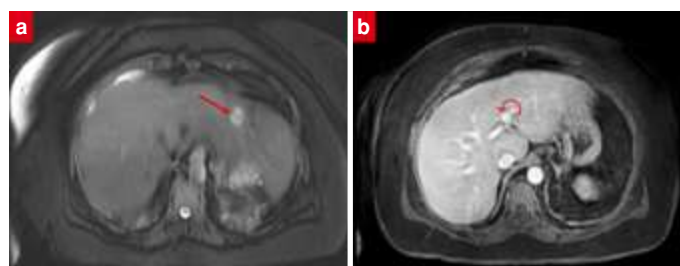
Pre-procedure T2-weighted MR imaging reveals a metastatic lesion in segment 2 (arrow) (a). Portal phase MRI demonstrates that the left portal vein remains patent (curved arrow) (b).
